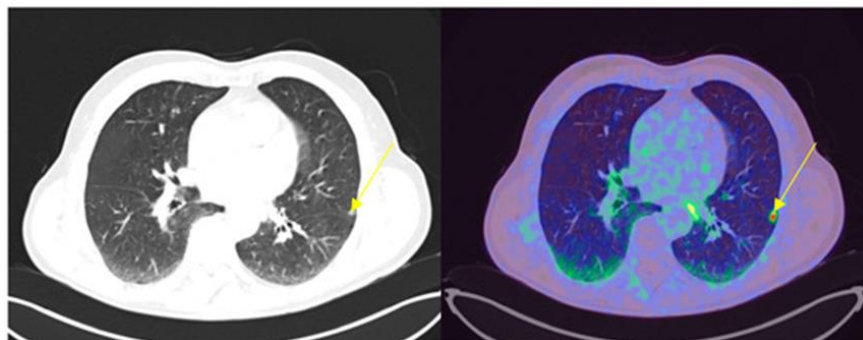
Pulmonary lesion (yellow arrow), nonspecific on CT, PSA: 0.77 ng/mL, DT-PSA: 6 months.
